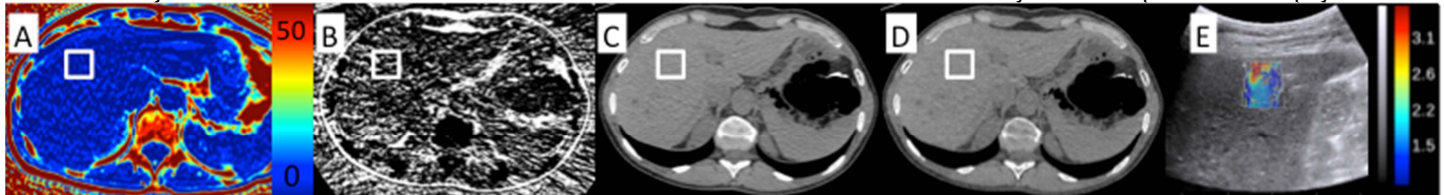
Representative images of MRI PDFF (A), DECT material decomposition (B), mono energetic CT-HU at 70keV (C) and 140keV (D) as well as an US-SW measurement (E). Because of the nearly similar attenuation values of fat and water a separation with DECT is very prone to artifacts (B).
